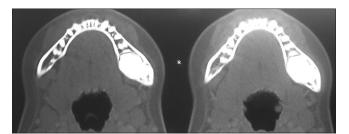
Computed tomography view of the odontoma
